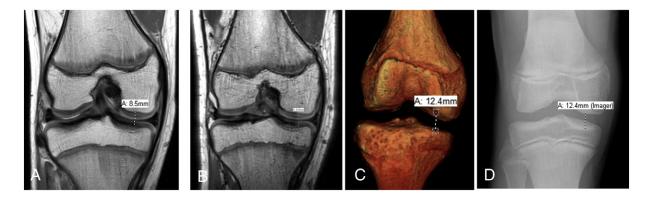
Medial joint space measurements on 2D PD (A), 3D PD (B), 3D model (C), and lateral X-ray (D) of knee. Notice the similar measurements on 3D model and lateral X-ray (12.4 mm) vs 2D and 3D MRI (8.5 mm).
